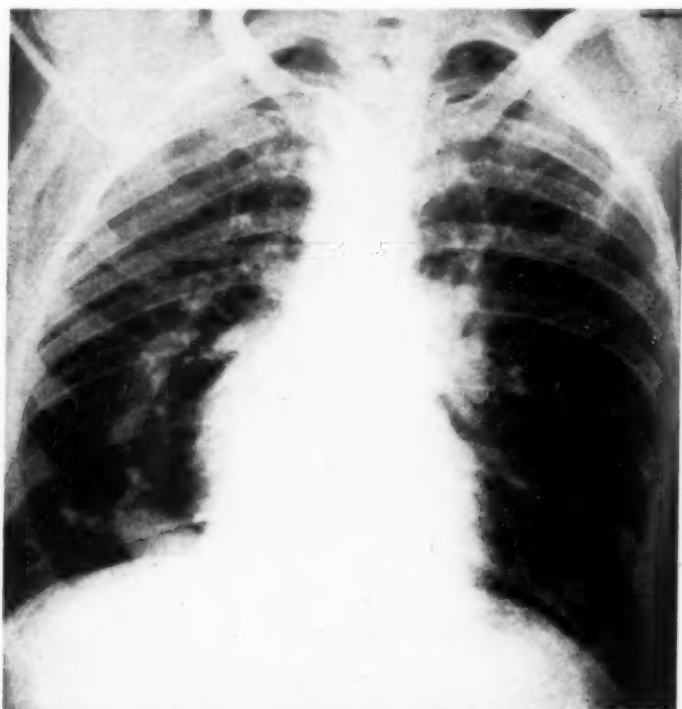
Anomalous Pulmonary Vein Entering Inferior Vena Cava.* Male, 27. Asymptomatic. Crescent-like shadow, right lower lung field found on routine chest roentgenogram. Frontal angiocardigram at 8.5 seconds. Note filling of left heart, pulmonary veins and aorta and simultaneous opacification of a vascular trunk draining blood from the right lung to a point below the diaphragm.
